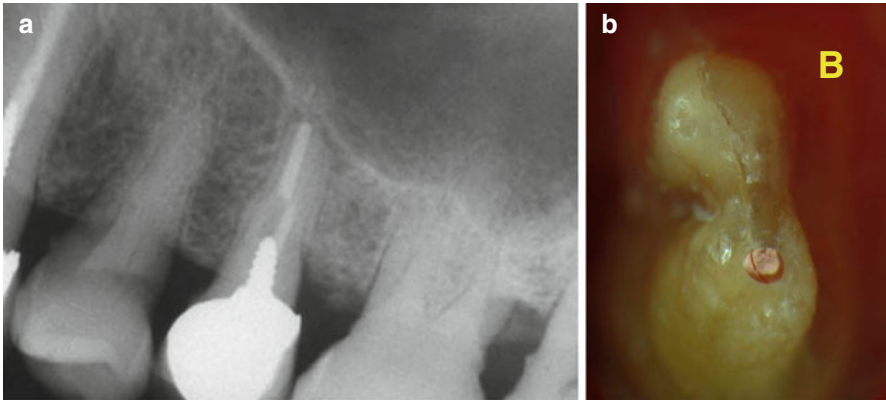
(a, b) The patient arrived at the dental office with a complaint about discomfort in “touching the tooth and when biting” and pointed to the maxillary second premolar. The tooth had been endodontically treated 4 years previously with gutta-percha, passive cementing of a serrated dowel in the palatal canal, and full coverage to the crown. Examination of the tooth revealed sensitivity to percussion and a 6 mm probing depth in the midbuccal area. The radiograph revealed two obturated canals and the dowel most likely placed in the palatal canal (a). A diagnosis of acute apical periodontitis was made. Since the endodontic prognosis for retreatment was poor, endodontic surgery procedure was suggested. The patient declined any surgery, and the tooth was extracted. Examination of the extracted tooth from the apices (b) shows the deep mesial concavity in the root trunk and the incomplete VRF from the buccal aspect toward the palatal area of the root
